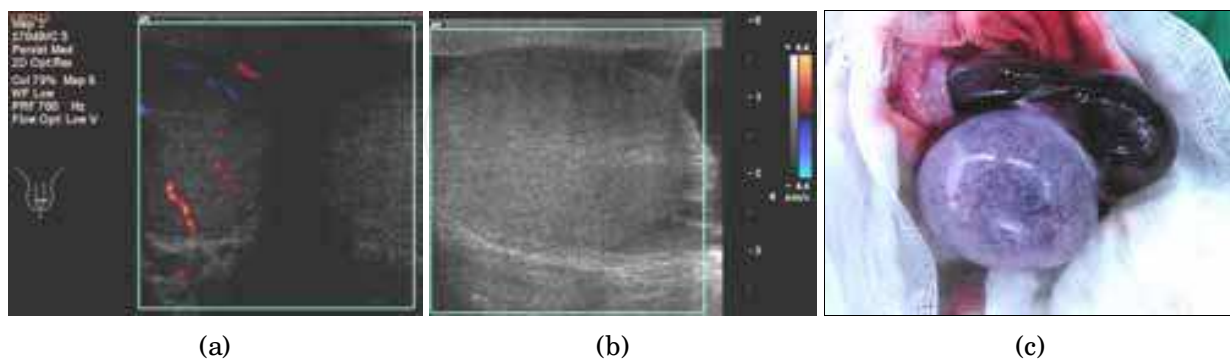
Testicular torsion. A 50-year-old male presented to the ER and complained of a sudden painful enlargement of his left testis over 1 day: (a, b) ultrasonography showed absent vascularity with a cystic lesion in the left testis. Testicular echogenicity had not changes; (c) emergent exploration confirmed a 360° torsion and necrotic change of the affected organ. A left-sided orchiectomy was performed
